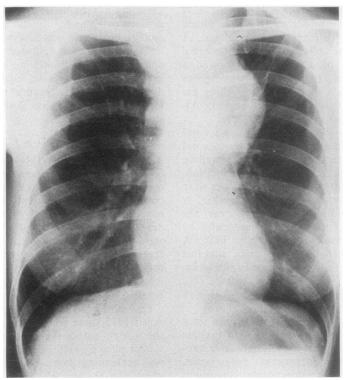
Case 2. Chest radiograph showing the mediastinal tumour.
